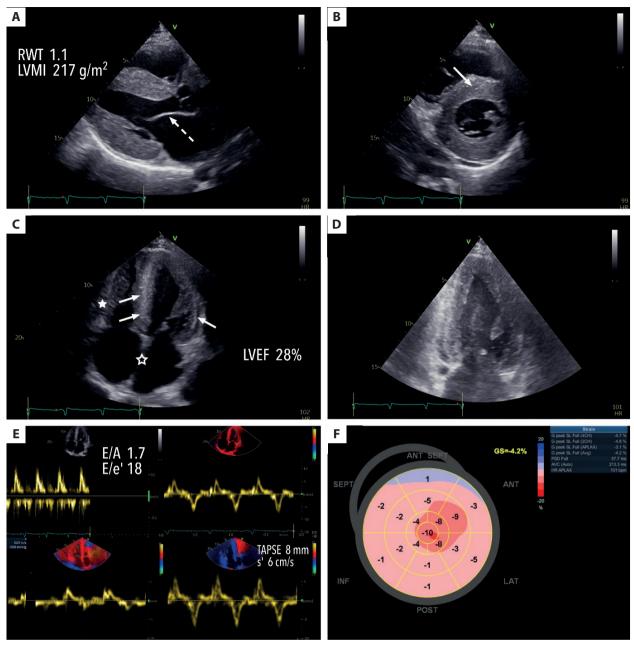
Findings in transthoracic echocardiography. Figures A-D showing increased thickness in all left ventricle segments, right ventricle hypertrophy (filled star), ground-glass myocardial wall appearance (simple arrow), left and right atrium enlargement. A. Parasternal long-axis view. Striped arrow indicates increased thickness of mitral valve. B. Parasternal short-axis view. C. Apical four-chamber view. A hollow star indicates increased thickness of interatrial septum. D. Apical two-chamber view with the focus on left ventricle. E. Pulse wave Doppler and tissue Doppler measurements showing 2. grade diastolic dysfunction and right ventricular systolic dysfunction. F. Bull's eye representation of global longitudinal strain with apical sparing
